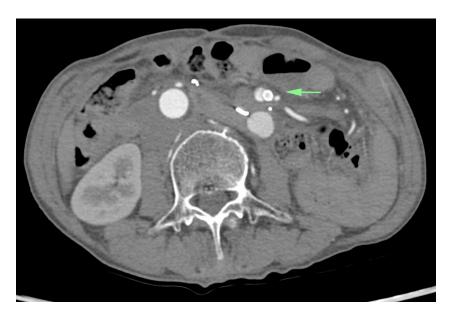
Follow-up abdominal CT scan at 3 months postoperatively showing changes consistent with superior mesenteric artery dissection and aneurysms. Mild dilatation of distal SMA branches was observed (the arrow).
